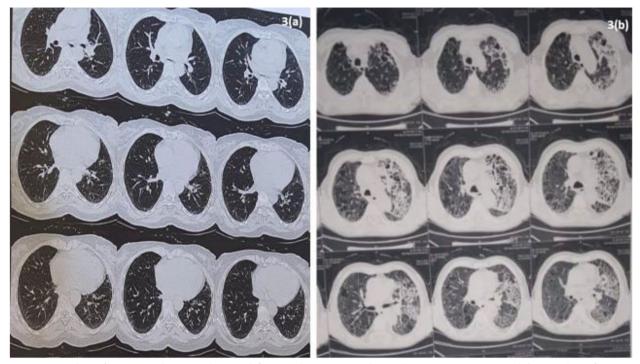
a HRCT chest of SSc patient showing early ILD with fine reticular opacities (Krebs von den Lungen-6 was 722 U/ml). b HRCT chest of SSc patient with advanced ILD showing patchy ground glass associated with reticular changes (Krebs von den Lungen-6 was 812 U/ml)
